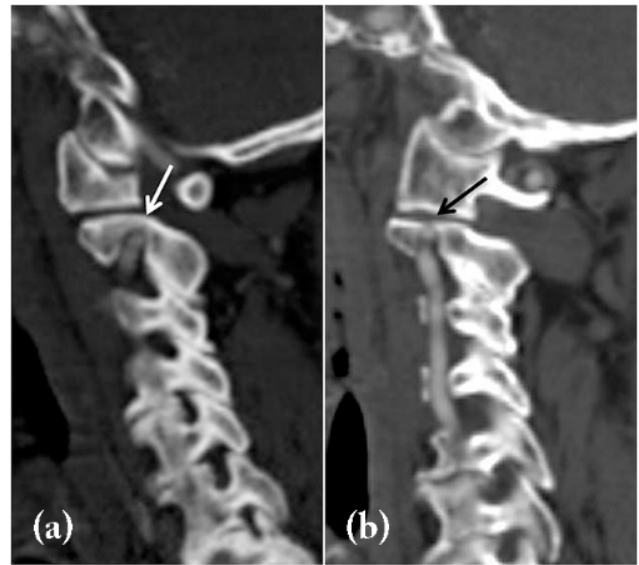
CT-angiography images of two different patients with high-riding VA. (a) Sagittal MPR image shows decrease of isthmus thickness (white arrow) and (b) sagittal MPR image shows decrease of internal height (black arrow)
